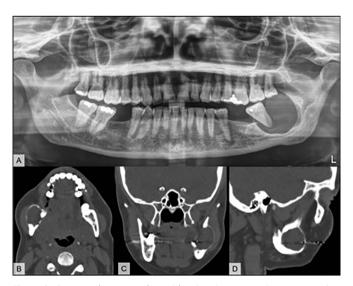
Computed tomography, evidencing, in panoramic reconstruction (A), well delimited hypodense area, associated with tooth # 38. On axial (B), coronal (C) and sagittal (D) sections, a well delimited hypodense lesion, surrounded by a thin layer of cortical bone can also be seen, associated with a discrete area of solution of continuity.
